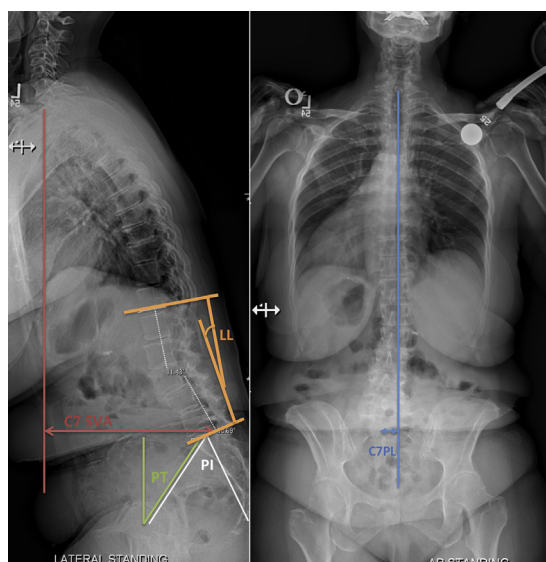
Lateral (left) and anteroposterior (right) long-cassette radiographs of a 65-year-old patient with severe positive sagittal malalignment. Colored lines demonstrate standard radiographic deformity measurements, including C7 sagittal vertical axis (SVA), pelvic incidence (PI), pelvic tilt (PT), lumbar lordosis (LL), and C7 plumb line for measuring global coronal alignment. See text for description of these measurements.
